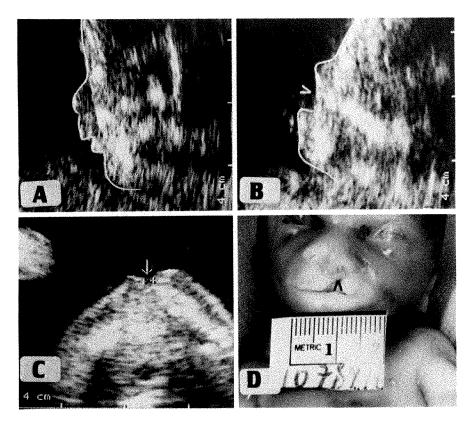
A, Sagittal median transvaginal ultrasonographic section of fetus in case 2, compatible with normal facial profile (contour). B, Sagittal left paramedian section of same fetus, through cleft lip (arrow), showing relative protrusion of mandible (pseudoprognathism). C, Tangential section of upper lip, demonstrating cleft lip (arrow). D, Cleft lip (arrow) in aborted fetus.
